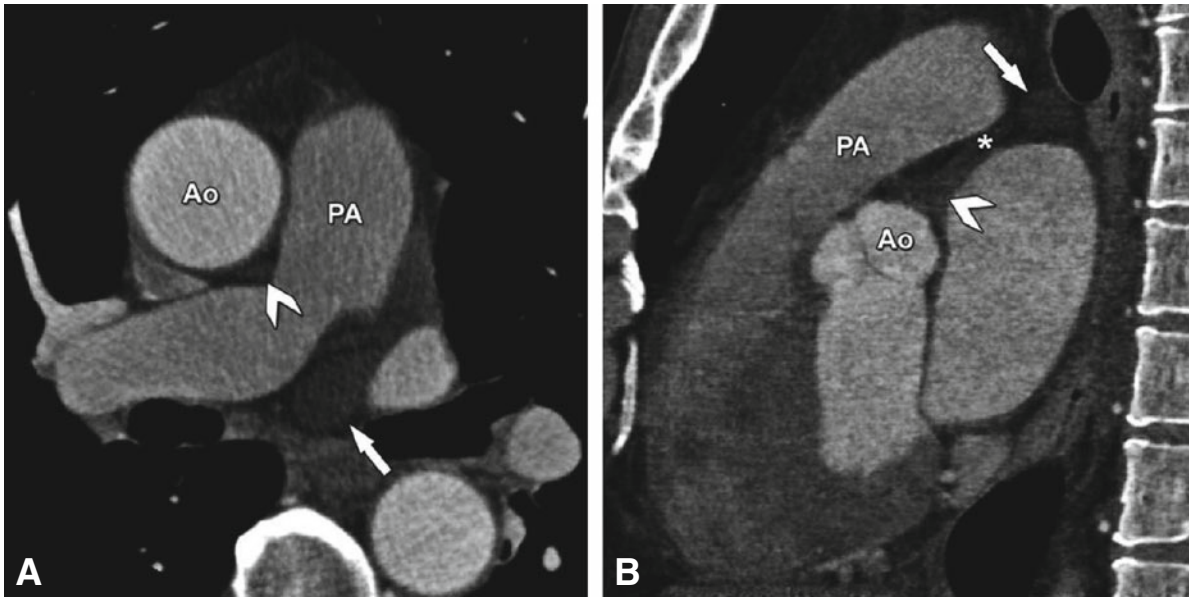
Pericardial recesses and sinuses need to be differentiated from effusions, lymph nodes, and dissections. Panels A and B show an example of a left pulmonic pericardial recess (*arrow*) in the groove inferior to the left pulmonary artery (PA). This recess commonly communicates (*asterisk* in Panel B) with the transverse pericardial sinus (*arrowhead* in Panel B), which is located posterior to the ascending aorta (Ao). Also communicating with the transverse sinus is the superior aortic recess (*arrowhead* in Panel A). The posterior pericardial recess (not shown) is also sometimes seen and is located posterior to the right pulmonary artery as part of the oblique pericardial sinus. The typical location and CT appearance (density of water, well-marginated, tapered configuration) allow pericardial recesses to be distinguished from mediastinal lymphadenopathy, pericardial effusions, and aortic dissection
